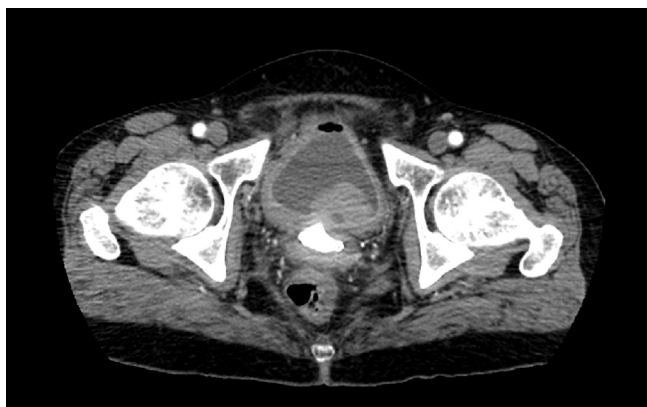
CT, transverse section, showing both the irregular enhancing bladder mass and radiopaque material in the vaginal canal.
